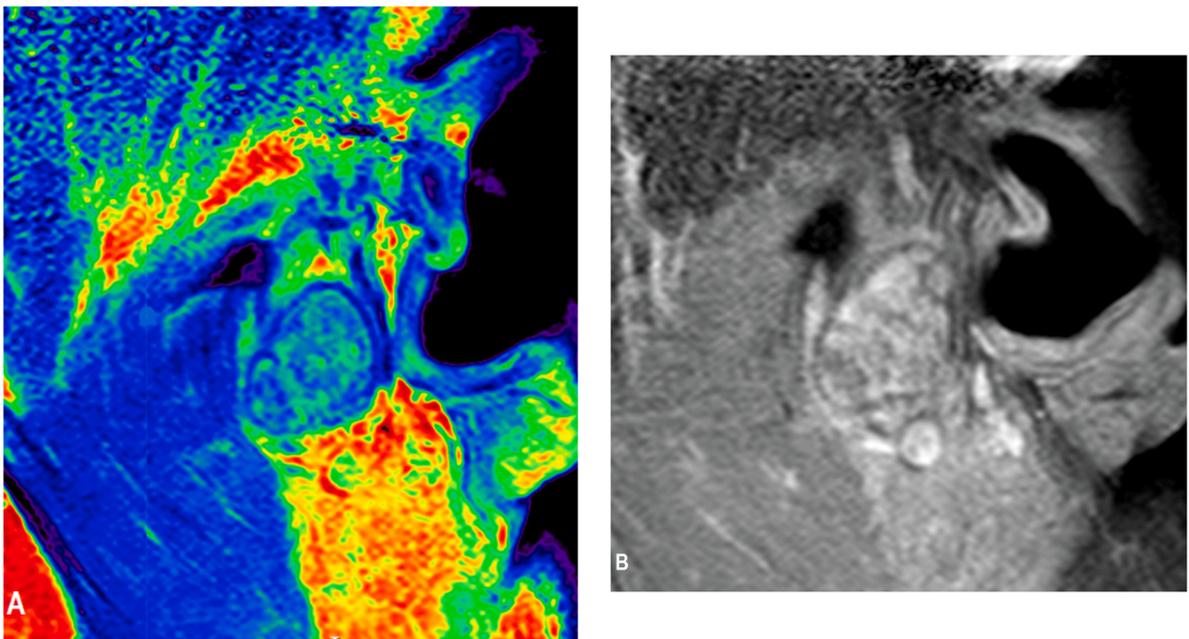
A and B - Magnetic resonance imaging of the left TMJ in a T1-weighted sagittal view, showing an oval-shaped lesion, surrounded by a low-signal halo and presenting a heterogeneous component compatible with high-signal calcifications. (A) Post-processed MRI by dynamic color enhancement.
